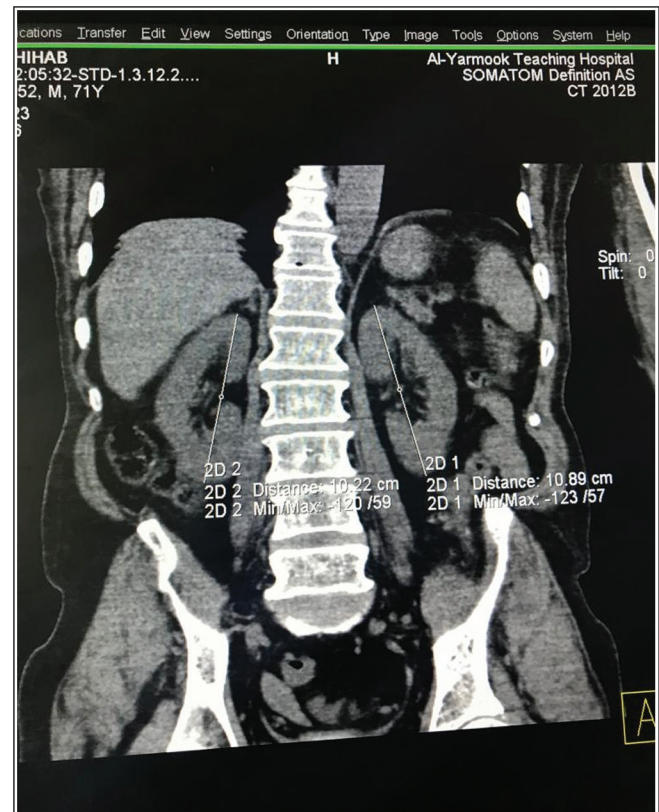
Abdominal CT scan reformatted coronal view, showing vertical right and left renal length measurements
